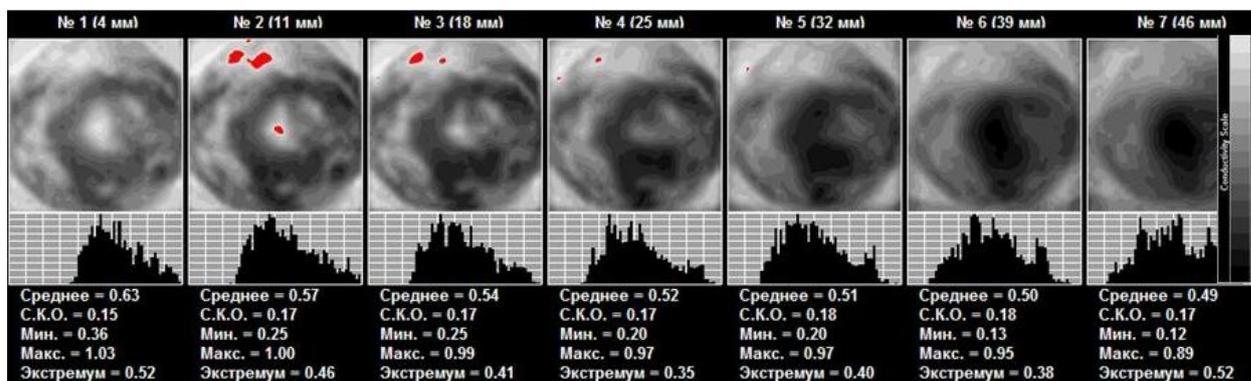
EIM. Mixed type of mammary gland structure. In the upper-outer segment of the left gland there is observed an an-impedance area, which is highlighted with red in two scan planes, 7x20 mm in size. ULTRASOUND: In the upper-outer segment of the right gland, there is a lesion with blurred contours and vascularization, 1.1x0.7 cm in size.
